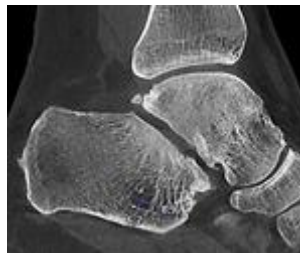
CBCT-image of the right ankle with the detailed mapping of the bone structure
